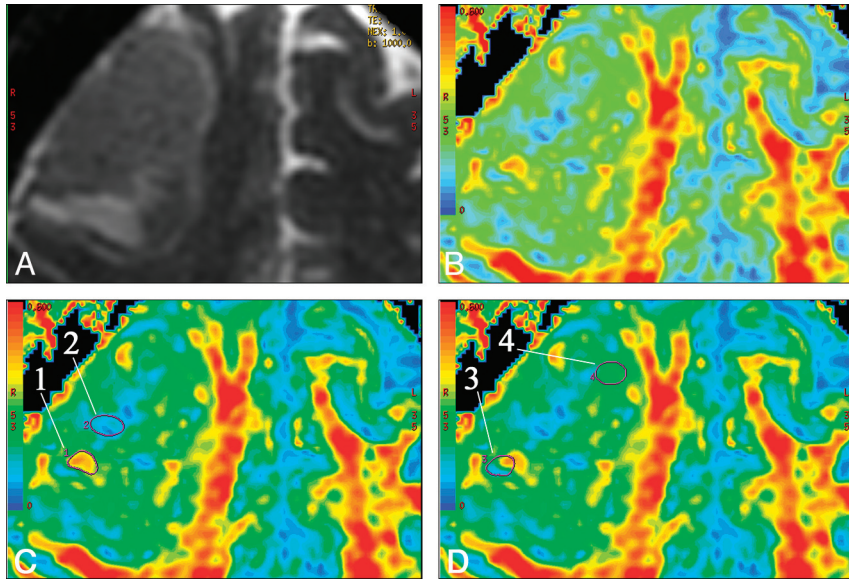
A, T2-weighted ($b = 0$) MR image shows a grade IV glioma in the right frontal lobe. B, FA map shows the different hues from blue to red in the tumor. C and D, FA maps at the same level show the method of region-of-interest selection. Region-of-interest 1 and region-of-interest 2 in C delineate red and blue areas that represent where the maximum FA and the minimum FA were measured. Region-of-interest 3 includes both blue and red portions and has a high contrast of color hue. The maximum SD is measured by region-of-interest 3 (SD = 0.125). The areas with homogeneous color hue have a low SD of FA. Region-of-interest 4 is an example of an area with a low SD (0.028).
